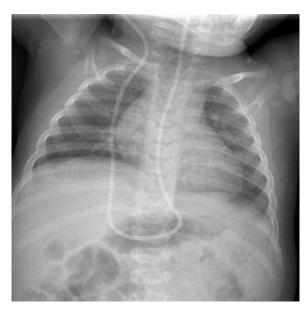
Chest and abdomen X-ray.
